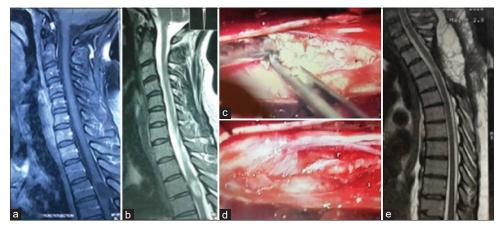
(a) Cervicothoracic T1-weighted magnetic resonance imaging (MRI) a hypointense tumor at T3-T4 level, (b) in T2-weighted MRI the mass is hyperintense, (c) intraoperative photograph; a white avascular tumor inside the cord, (d) after total removal, (e) postoperative T2-weighted MRI which is clear from residue.
